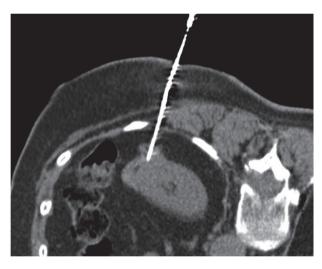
A 75 years old woman with solid exophytic lesion of left kidney. CT-guided CNB on prone position showed a renal cell carcinoma
